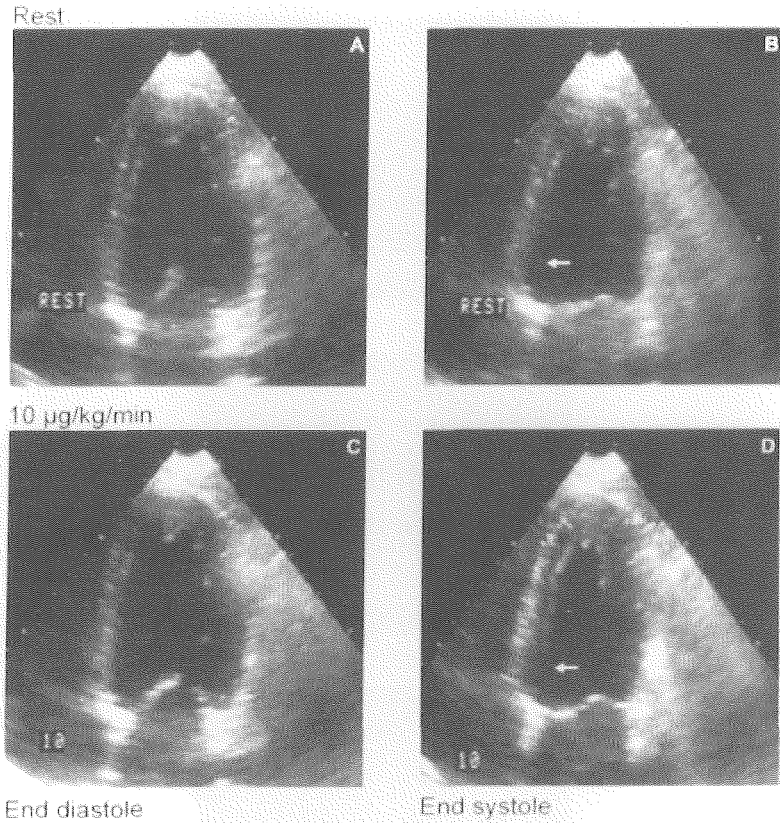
Representative example of myocardial viability as demonstrated by low-dose dobutamine stress echocardiography. Top panels show resting apical four-chamber views at end diastole (A) and end systole (B). Marked dyssynergy is present in the posteroseptal segment (arrow). Bottom panels show the same views during dobutamine infusion ($10\mu\text{g}/\text{kg}/\text{min}$). At end systole a clear improvement in wall thickening has occurred after the inotropic stimulus (arrow in panel D).
